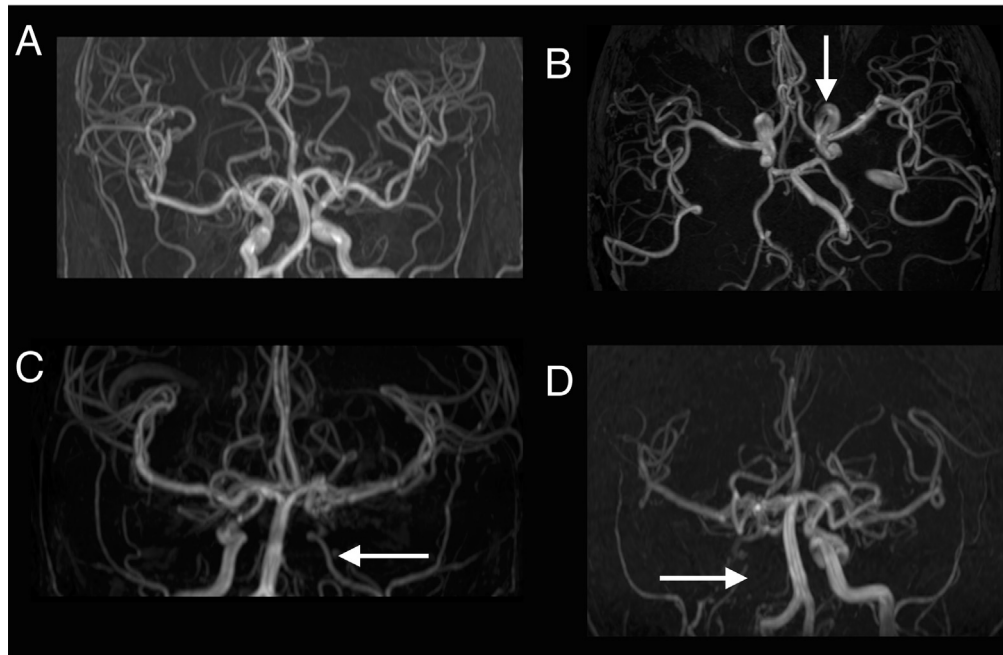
Vasculopathy on magnetic resonance angiography was graded according to severity of signal loss: (A) grade 0: normal; (B) grade 1: minor signal attenuation (turbulence) and normal appearing vessel on magnetic resonance imaging; (C) grade 2: obvious signal attenuation, but presence of distal flow (stenosis); (D) grade 3: signal loss and no distal flow (occlusion). Grade 4: occlusion with collaterals (moyamoya) not shown. The arrows show areas with named abnormalities. Reprinted with permission from Dlamini et al.¹⁸
